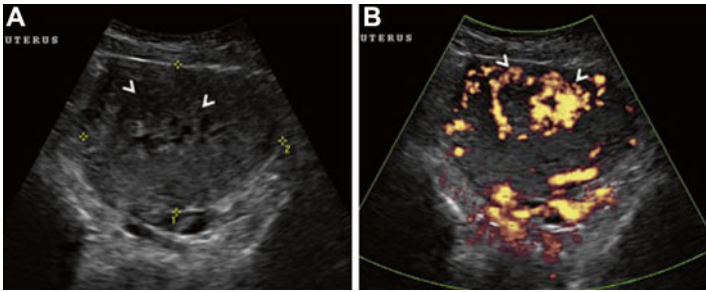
Complete hydatidiform mole. Grayscale (a) and power Doppler (b) sonographic images demonstrate cystic spaces within the endometrial cavity with increased vascularity (arrowheads). No fetus or gestational sac is seen (Reprinted from Shanbhogue et al. [12], with permission from Elsevier)
